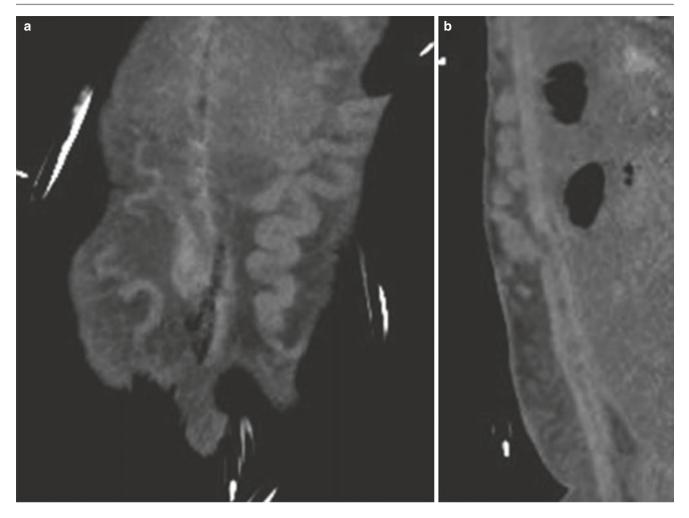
Non-contrast CT of patient with subcutaneous plexus of veins developing after vena cava occlusion, showing penetration of some vessels through the rectus muscle sheath. (a) Coronal plane, anterior to rectus muscles. (b) Sagittal plane
